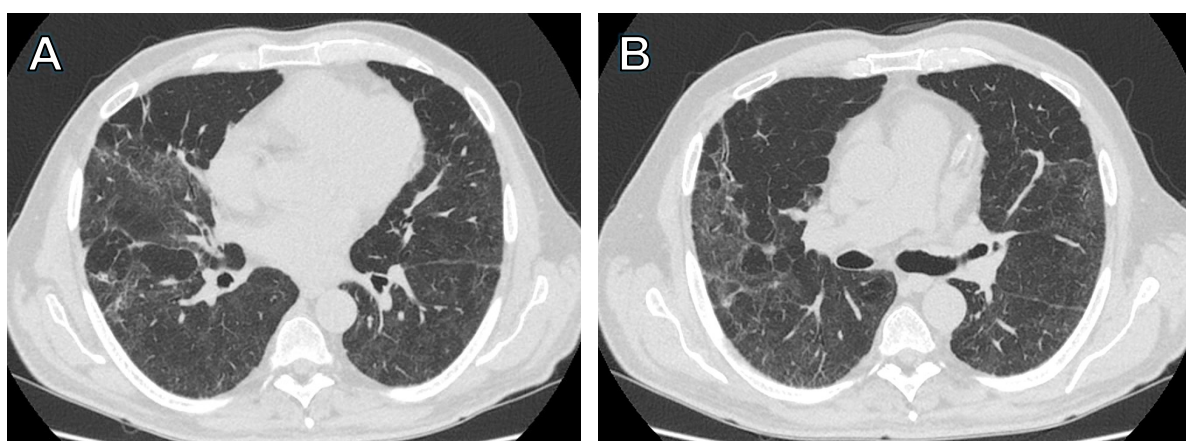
CT performed six months after COVID-19 infection showing radiological features consistent with organizing pneumonia. The patient is a 71-year-old male who was previously admitted to the ICU with SARS-CoV-2 pneumonia, requiring ventilatory support with high-flow nasal cannula (HFNC).
